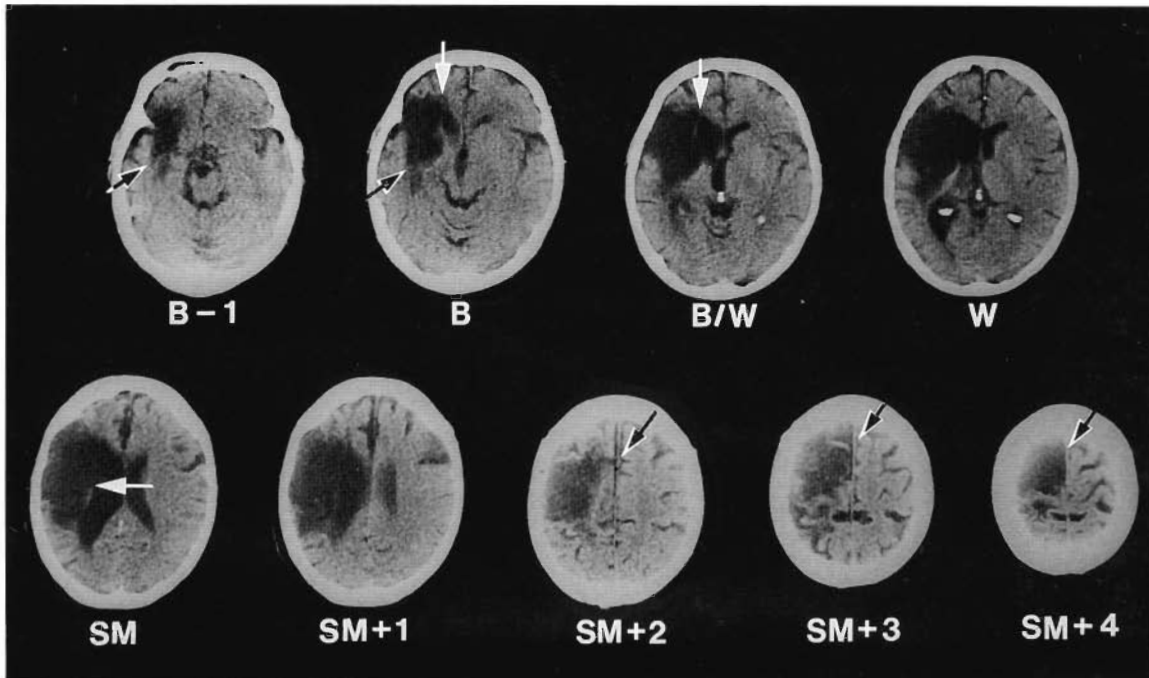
CT scan for patient RR, a 60-year-old man who entered the C-ViC program 21 MPO and had a poor response to C-ViC treatment. The basic lesion site pattern associated with no recovery of spontaneous speech was present in the medial ScF area on slices B and B/W (white arrows), plus the $M\frac{1}{3}$ PVWM area on slice SM (white arrow). The total extent-of-lesion rating for medial ScF area plus the $M\frac{1}{3}$ PVWM area was 9.65. In addition, extensive lesion was present in both the supraventricular area including SMA/cingulate gyrus area (black and white arrows) and the temporal lobe area, including the subcortical temporal isthmus area on slices B-1 and B (black and white arrows). The CT scan was done 4 years postonset.
